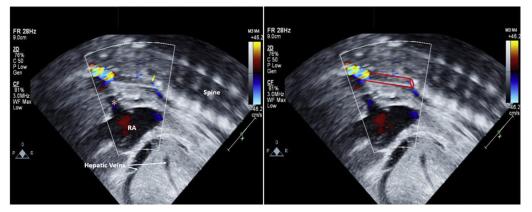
A subcostal sagittal view with color Doppler shows evidence of blood flow (*blue* flow) near the tip of the cannula (*yellow arrow*) in the distal portion of the vessel. It remains apparent that the cannula is not descending through the SVC (*asterisk*) into the right atrium (RA), as would be expected. In the accompanying image, the distal portion of the cannula is outlined in *red*.
